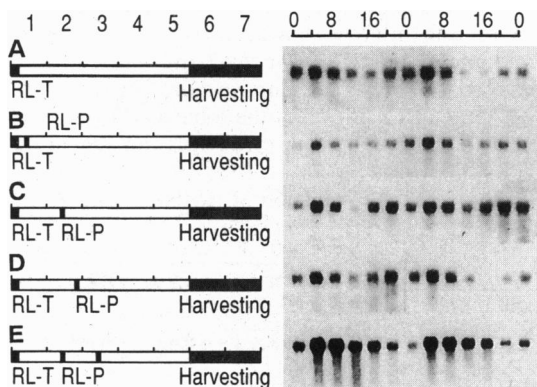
Developmental stage-specific light induction of rhythmic Cab mRNA accumulation in tobacco seedlings. Seeds were uniformly sown at 0800 (CT0), irradiated for 3 h with red light (CT0–3), and returned to darkness. Germinating seeds were then, with the exception of control seeds (*A*), illuminated again with a short (5 min) red light pulse at 12 h (*B*), 36 h (*C*), 44 h (*D*), or 36 h and 60 h (*E*) after sowing and returned to constant darkness. RL-T, 3-h red light treatment; RL-P, 5-min red light pulse. (Left) Numbers indicate the days after sowing. (Right) Numbers show the CT at the days of harvesting. Each lane contains 20 μ g of total RNA. Filters were uniformly exposed for 48 h.
